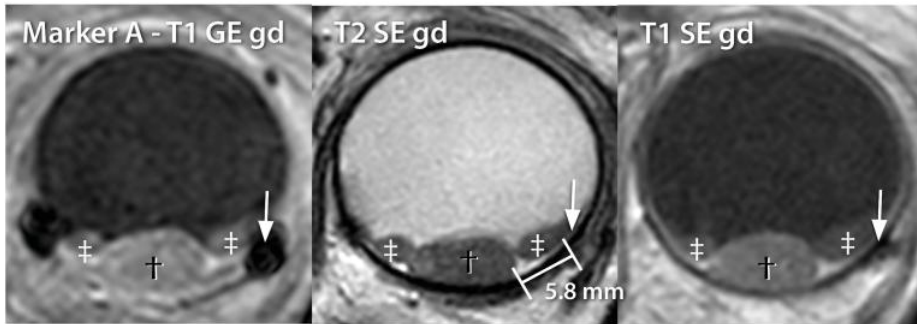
Scans to visualize the marker-tumor relation of a UM patient after contrast administration. Retinal detachment (double dagger) can be differentiated from the tumor (dagger) as it does not enhance after contrast administration. For each marker a T1-weighted GE, T2- and T1-weighted SE were acquired. Note that on the T1-weighted gradient echo scan the marker (arrow) appears bigger and is therefore easier localized compared the both spin echo sequences.
